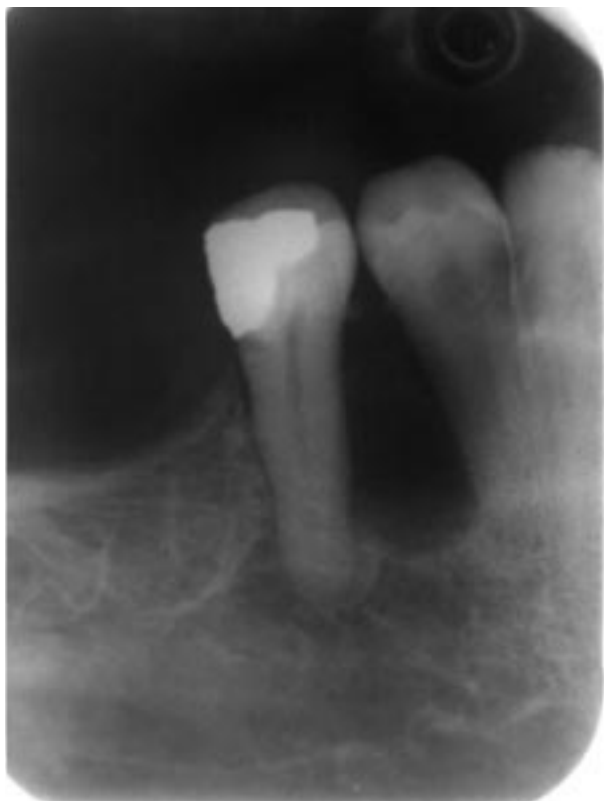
Radiographic appearance of the lesion.
